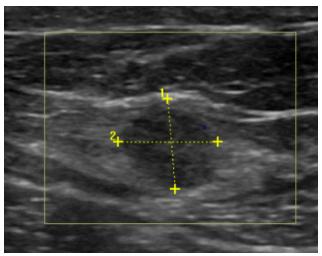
Ultrasound showed a nodular mass at the union of oblique muscles and rectus abdominis muscle compatible with lymph node.
